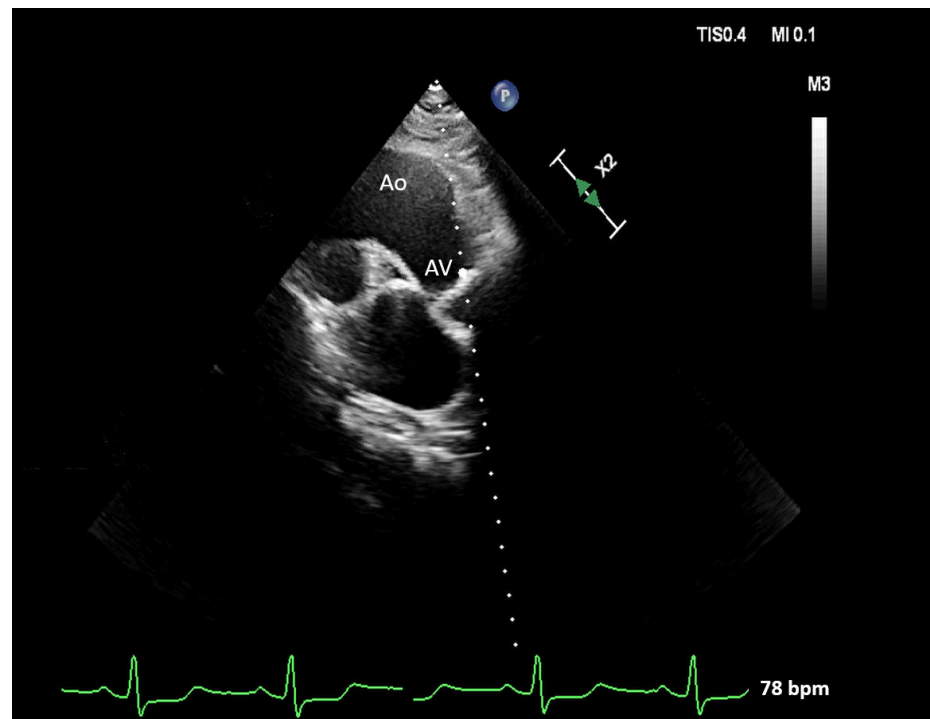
Right parasternal view provides an optimal Doppler readout of the counter transaortic flow. The ascending aorta (Ao) and aortic valve (AV) are registered.
